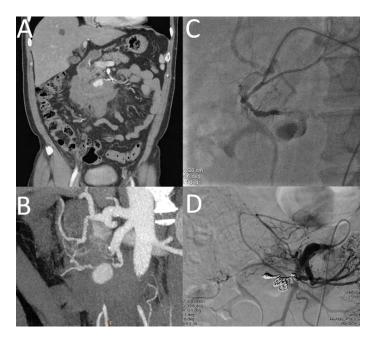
Axial and coronal views of computed tomographic angiography (CTA) demonstrated a ruptured saccular pseudoaneurysm of inferior pancreaticoduodenal artery (PDA) with peritoneal hemorrhage (Panel A). Reconstruction image of CTA depicted a saccular pseudoaneurysm of inferior PDA (Panel B). Digital subtraction angiography disclosed a ruptured saccular pseudoaneurysm of inferior PDA (Panel C) with extravasation and the transcatheter embolization with coil was carried out successfully (Panel D).
